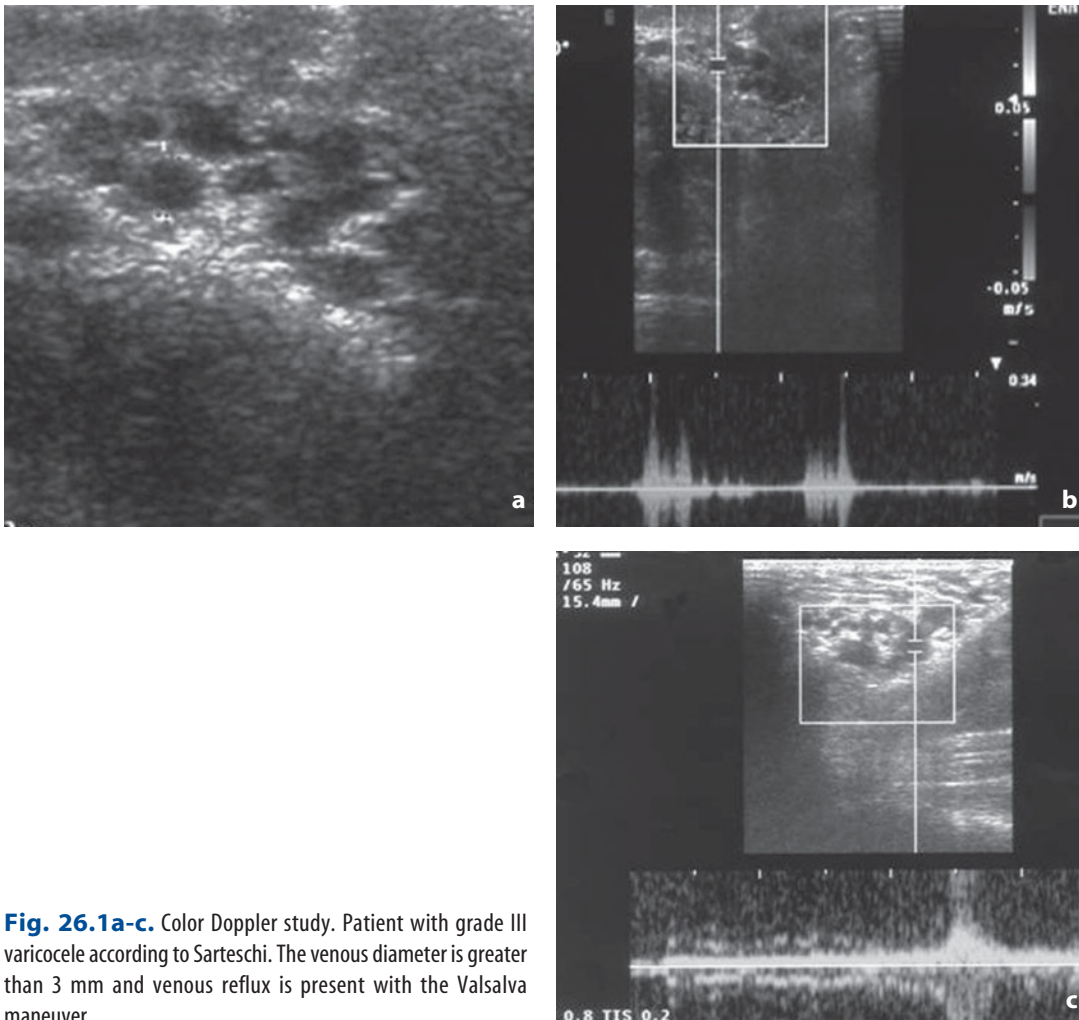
Color Doppler study. Patient with grade III varicocele according to Sarteschi. The venous diameter is greater than 3 mm and venous reflux is present with the Valsalva maneuver
